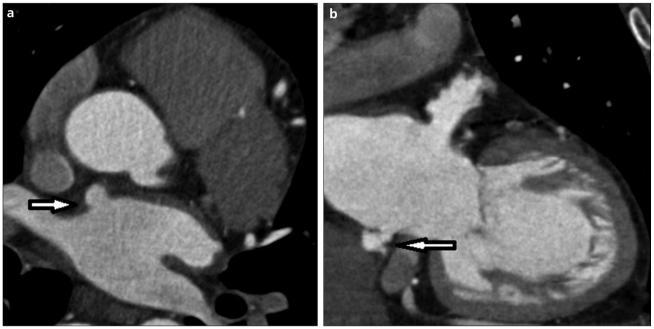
a, b. Typical appearance of atrial diverticula and accessory appendages in different patients. CT image (a) shows an atrial diverticulum with a broad base and smooth contour (*arrow*). CT image (b) demonstrates an accessory appendage with an irregular contour and a narrow ostium (*arrow*).
